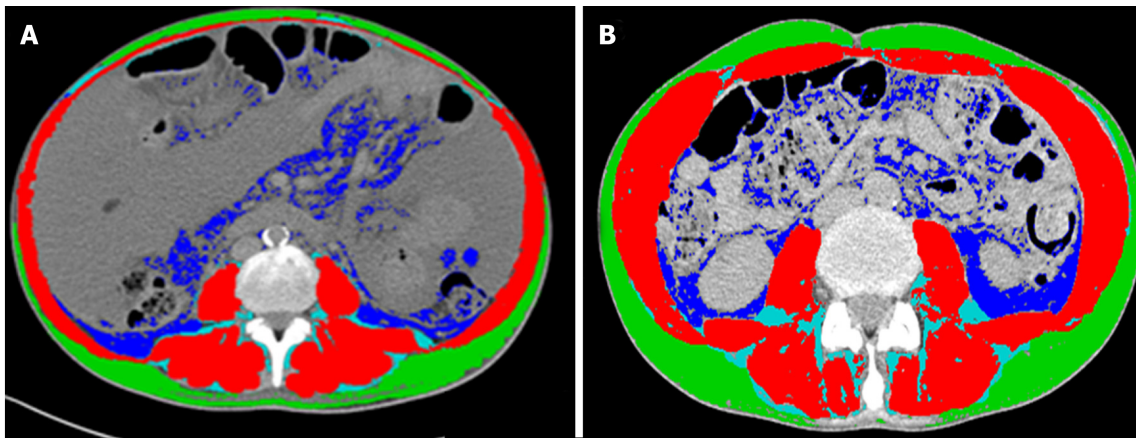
Computed tomography images used for the muscularity assessment of patients with cirrhosis. Comparison of two cirrhotic patients with (A) and without (B) sarcopenia. Muscle mass is highlighted in red, intra and intermuscular fat in light blue, subcutaneous fat in green and visceral fat in blue.
